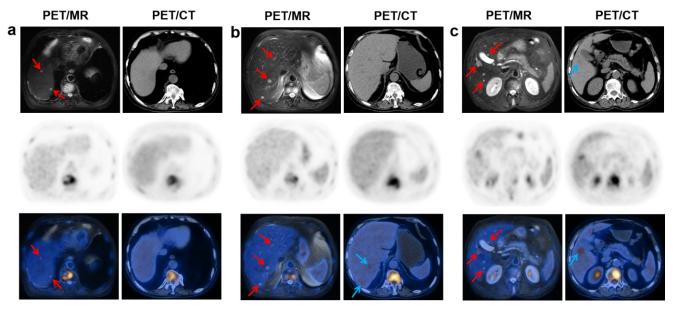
Comparison of a patient with liver metastasis scanned with GE Discovery VCT 64 scanner for PET/CT (a-c, right row) and PET/MR (a-c, left row). Positron emission tomography/MR detected more liver metastases compared to PET/CT.
